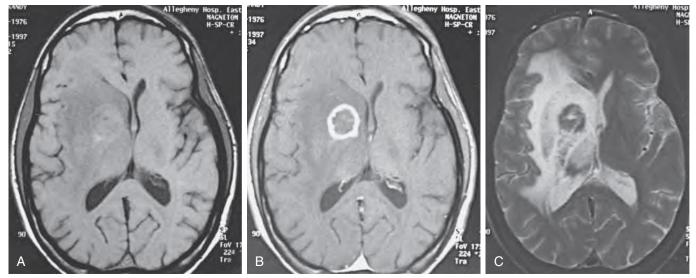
Magnetic resonance imaging of the brain (same patient as shown in Fig. 90.1) reveals 2-cm, round, ring-enhancing lesion in right lentiform nucleus with associated vasogenic edema and midline shift to the left. (A) T1-weighted image reveals ill-defined area of low attenuation. (B) T1-weighted image after administration of gadolinium reveals ring enhancement of the abscess. (C) T2-weighted image shows hypointensity of rim of abscess with large area of high signal intensity consistent with cerebral edema.
